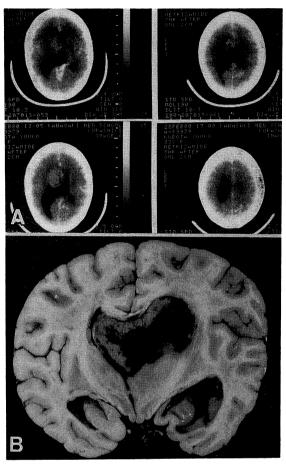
A: CT of case 1 showing a left intraventricular tumor. B: Coronal section of the cerebral hemispheres of case 2 through the mammillary bodies showing a left intraventricular tumor.
